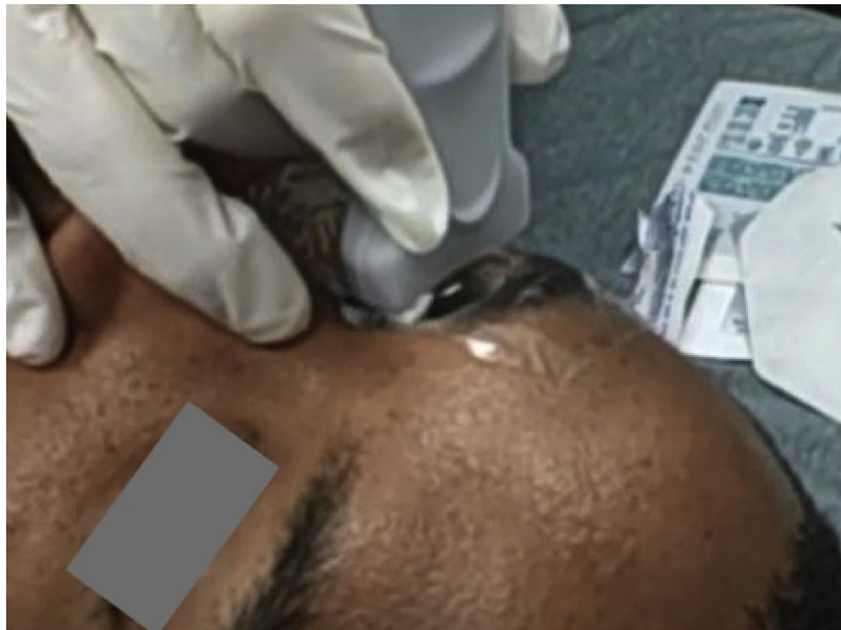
Ocular B-scan with a transverse probe position. The probe face is coated in ultrasound gel and positioned on the opposite conjunctival surface parallel to the limbus.
